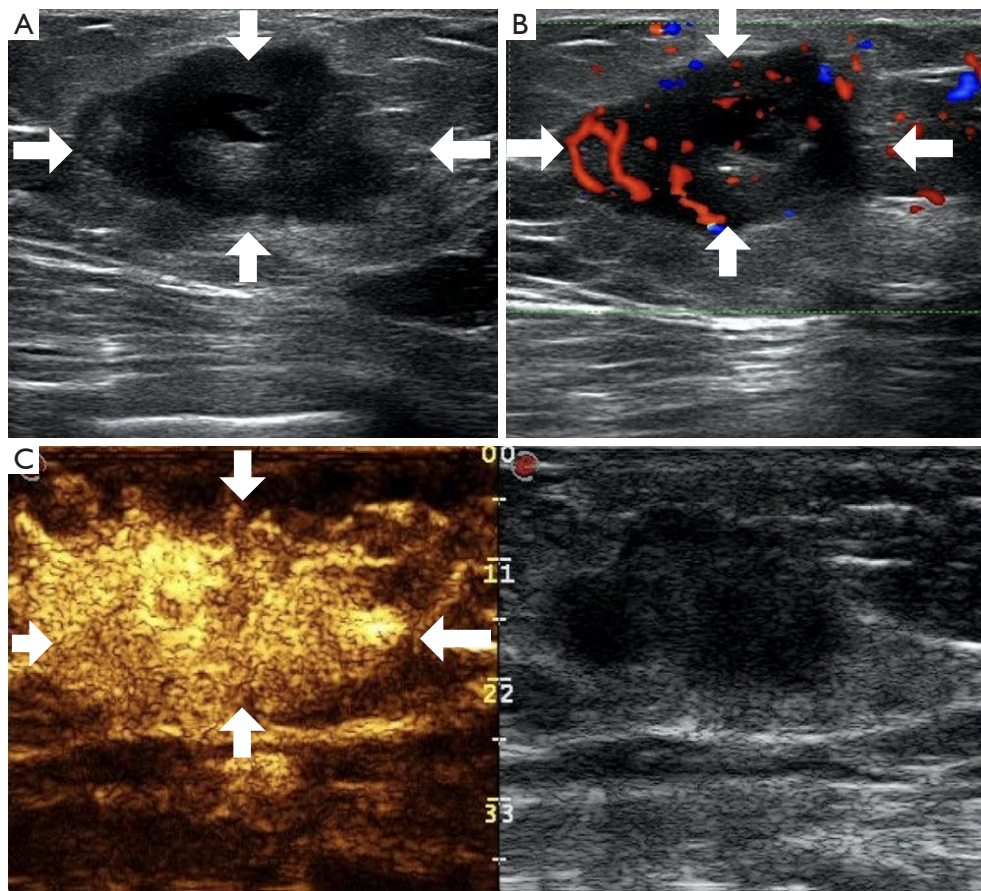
A 51-year-old woman with breast cancer on the right side. (A) B-mode ultrasound image showed irregular hypoechoic lesions (white arrows) with unclear boundaries. (B) Color Doppler flow imaging showed a grade III flow distribution* (white arrows). (C) CEUS showed high enhancement, irregular shape, and increased volume on CEUS, accompanied by penetrating vessels (white arrows). *, according to Adler blood flow grading results. CEUS, contrast-enhanced ultrasound.
